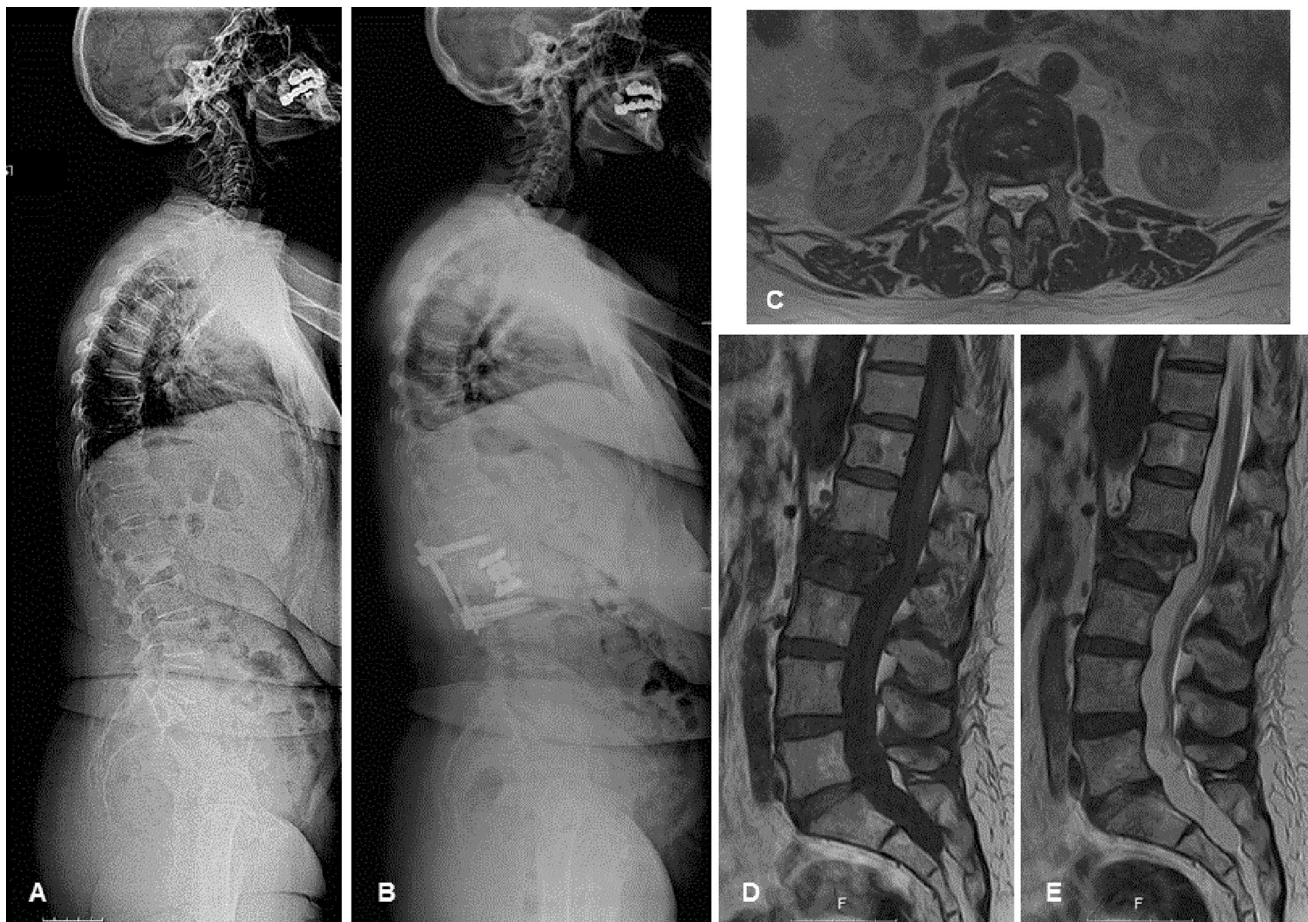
Sample case of 3,B,2 patient treated with L2 corpectomy and posterior fusion. a Preoperative full spine lateral x-ray; b postoperative full spine lateral x-ray; c axial MRI of L2 VBON; d T1-weighted MRI of the lumbar spine; e T2-weighted MRI of the lumbar spine
